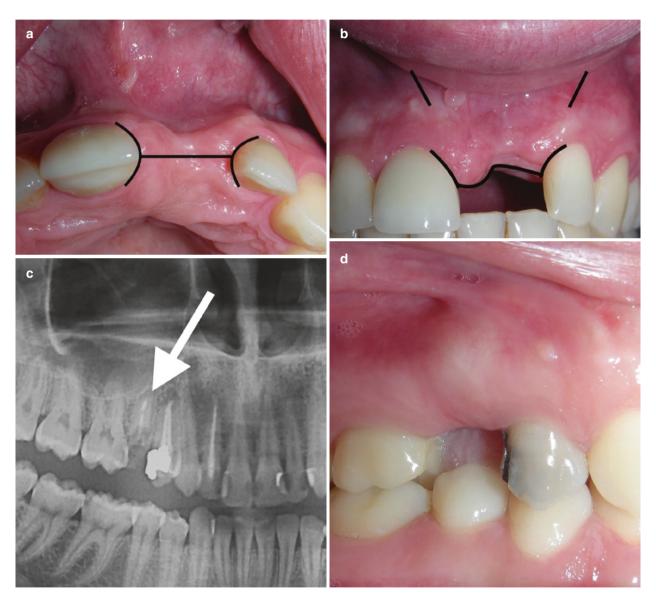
(a, b) "H" and accessory vertical/oblique incisions. (a) A sketch of a typical H incision – occlusal view. (b) H incision – frontal view with the position of accessory oblique incisions that are frequently indicated in cases where GBR is performed. In comparison with the three-sided MPF, gingival recession is less likely to occur. (c) Preoperative radiograph of the decayed root that is indicated for extraction. The tip is close to the sinus floor (*arrow*). (d) Clinical situation following the healing of the extraction wound. (e) Ideal condition for an implant site – occlusal view. (f) The implant is placed after H incision flap has been raised. (g) Lateral window SFE is performed via accessory
